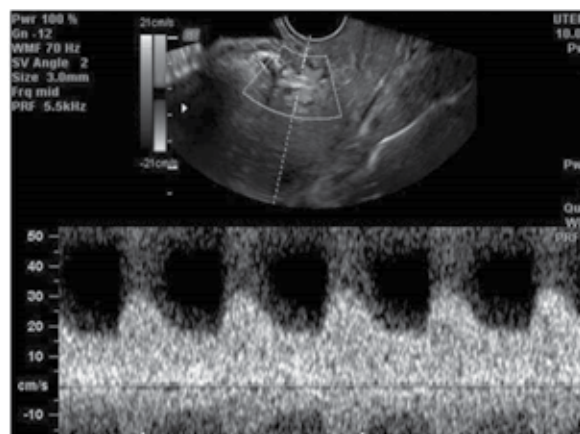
Doppler image of lower segment caesarian section scar AVM.
